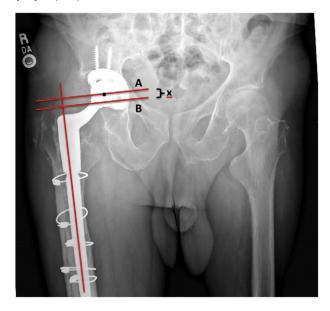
Subsidence was determined by measuring the distance from the center of the femoral head (A) to the tip of the trochanter (B) immediately post-operatively and at final follow-up. Magnification was corrected by comparing the actual and radiographically determined femoral head sizes.
